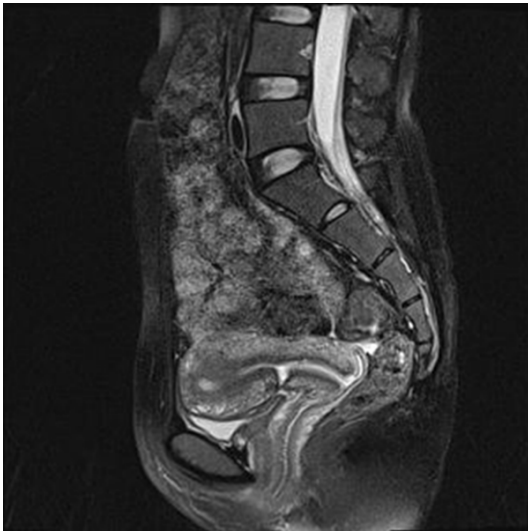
MRI image of one patient before and 6 months after the laparoscopic repair. MRI before surgery showed the presence of a reservoir-like pouch on the anterior wall of the uterine isthmus at the site of a previous cesarean delivery scar.
